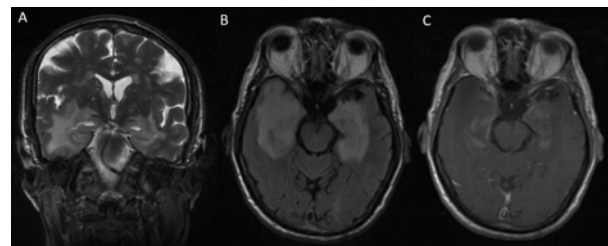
Coronal T2 (A) and axial FLAIR (B) brain MRI showing bilateral hyperintense medial temporal lobes, and axial T1 brain MRI with gadolinium (C) showing bilateral heterogeneous contrast enhancement.
